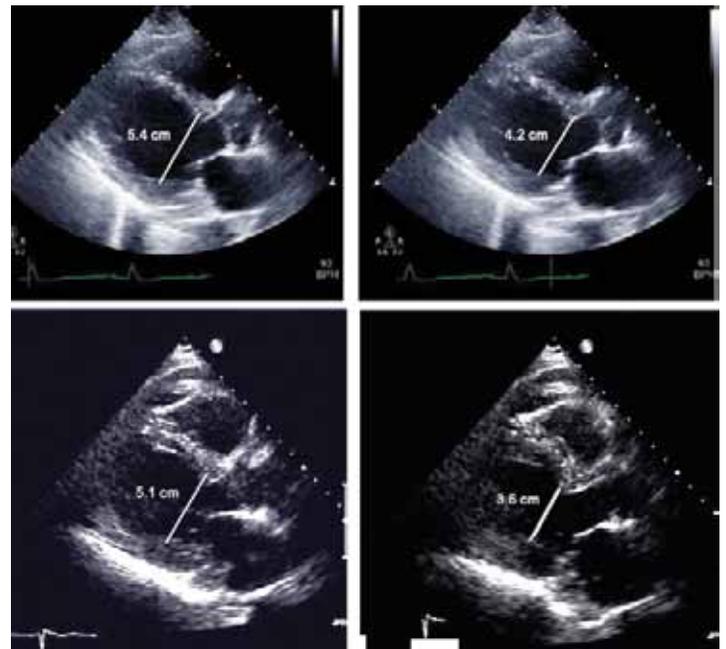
Two-dimensional echocardiography demonstrating (A) left ventricular end diastolic diameter on admission (5.4 cm); (B) left ventricular end systolic diameter on admission (4.2 cm), thus fractional shortening is 22%, which equates to an LVEF of 37%; (C) left ventricular end diastolic diameter at day 7 (5.1 cm); and (D) left ventricular end systolic diameter at day 7 (3.6 cm), which equates to an increase in fractional shortening of 29% and LVEF 50%.
